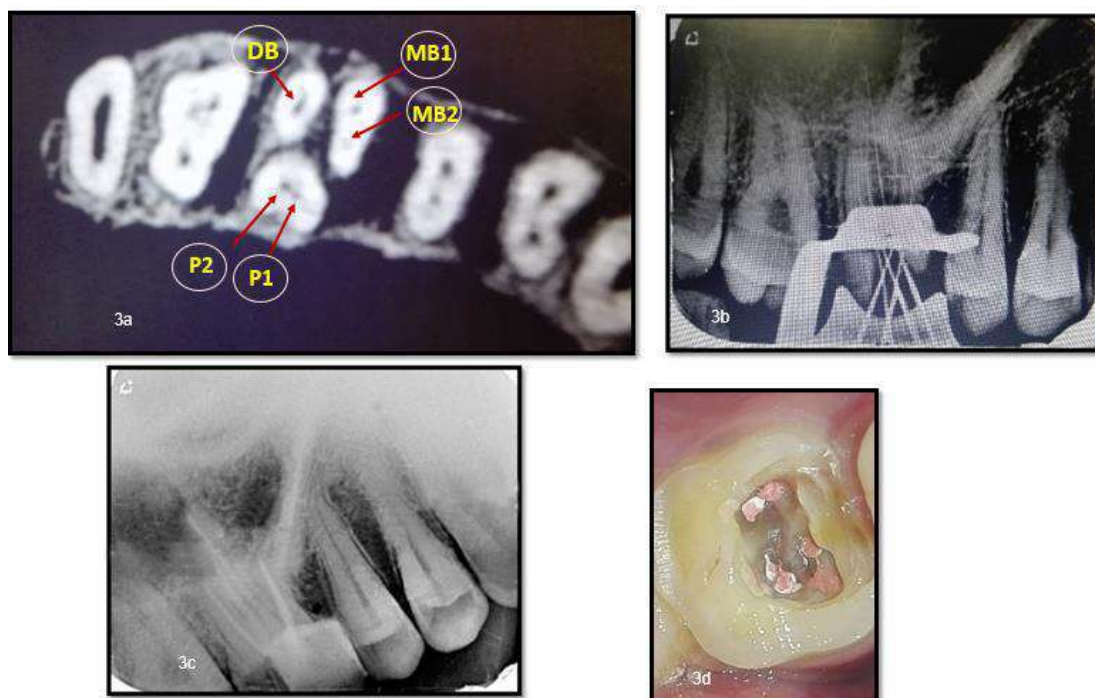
3a. Working length determination, 3b. Post-obturation radiograph, 3c. Clinical image showing 5 canal orifices, 3d. CBCT image
